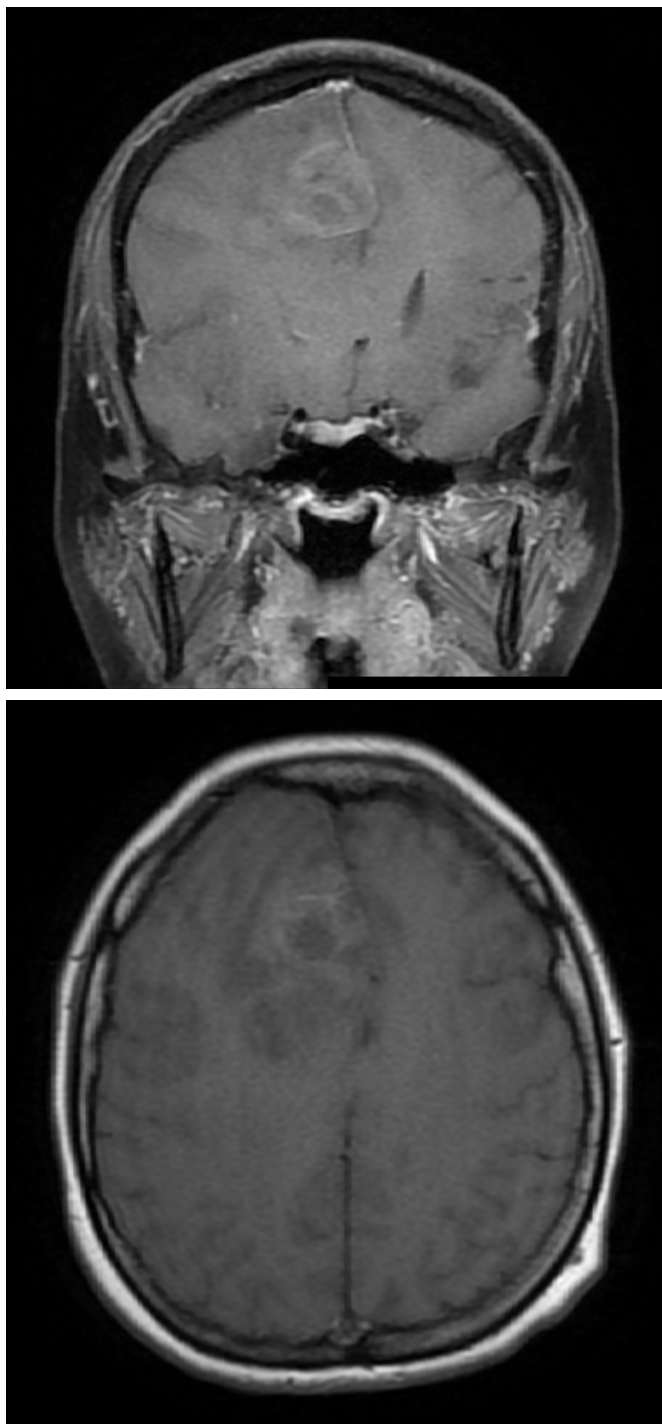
Cranial MRI of the patient
